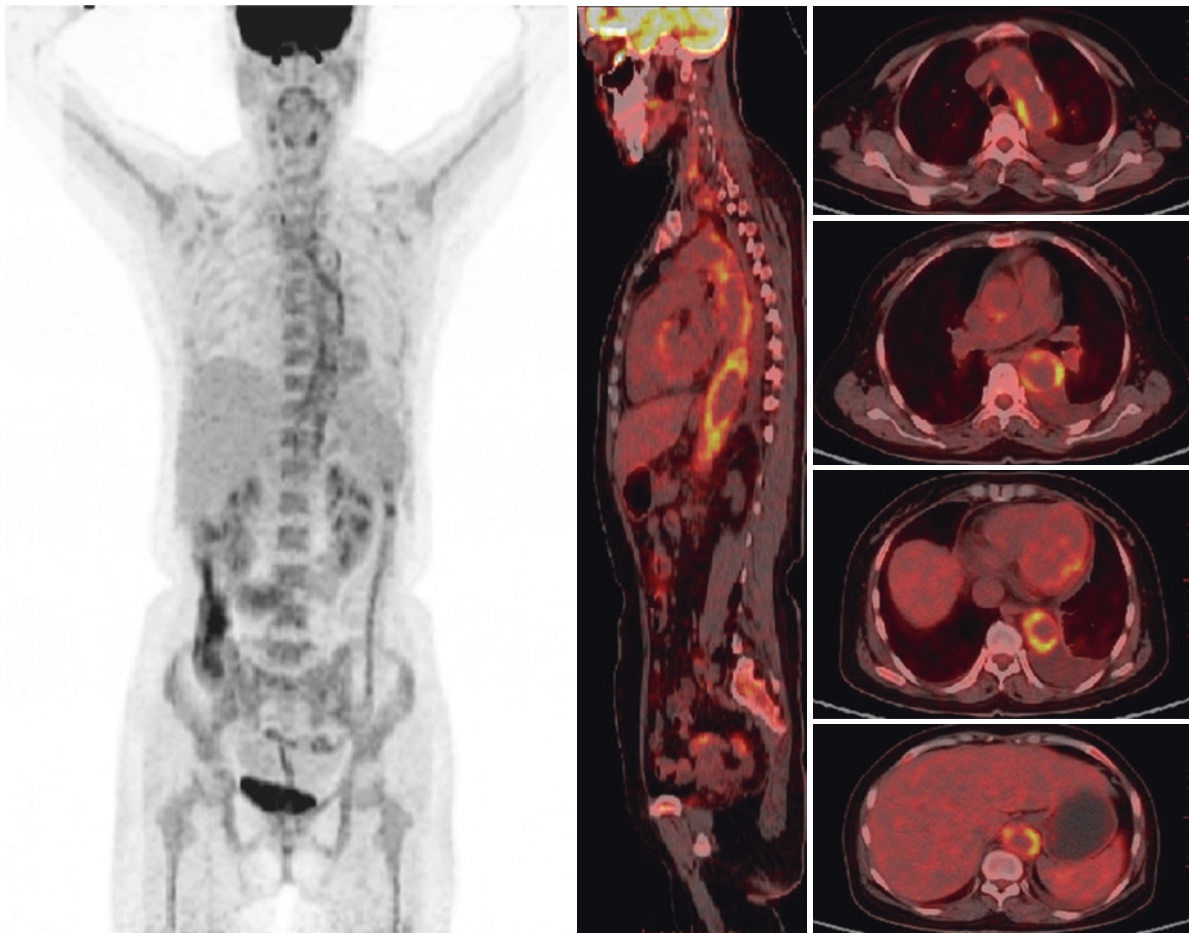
FDG PET/CT images
